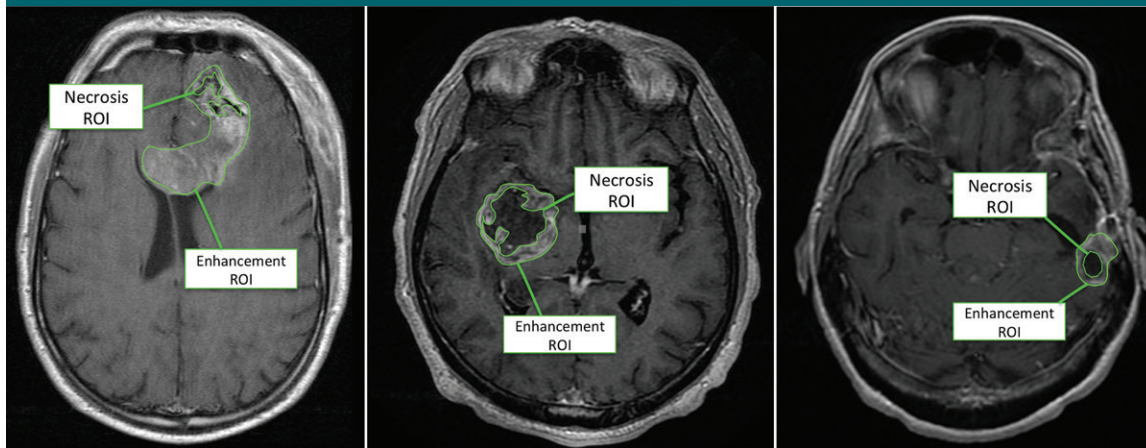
Example axial T1-weighted postcontrast MR images show necrosis and enhancement ROIs.
